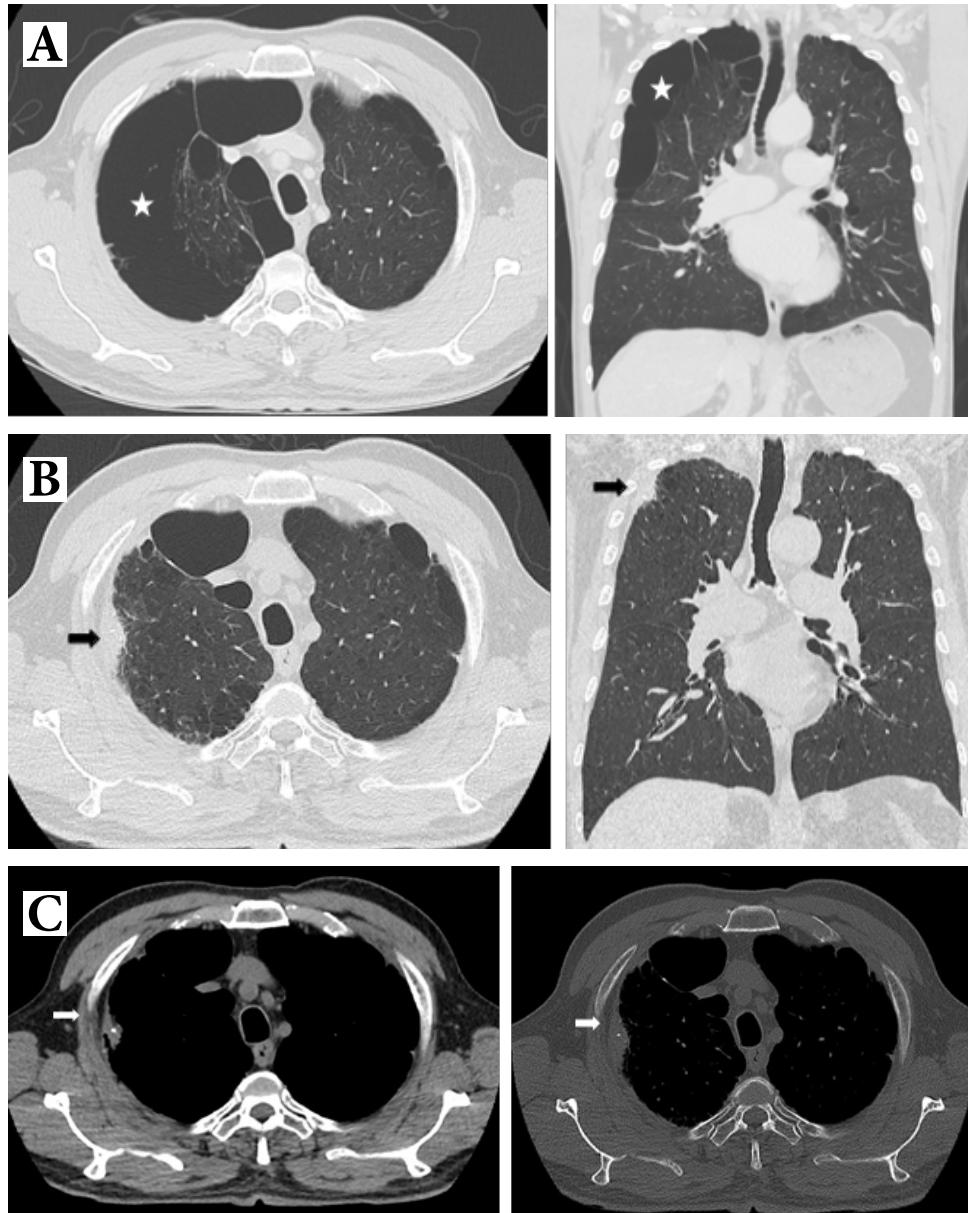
Conventional chest CT in (A) lung window on axial and coronal views shows a few lung blebs (white stars) both upper lobes. 17 months later, his follow-up chest high resolution computed tomography (HRCT) in (B) lung window on axial and coronal views shows regression of the lung bullae (black arrows) in both upper lobes with new pleural thickening and a few small calcifications visualized in (C) axial mediastinum and bone window (white arrow) in right upper lobe.
